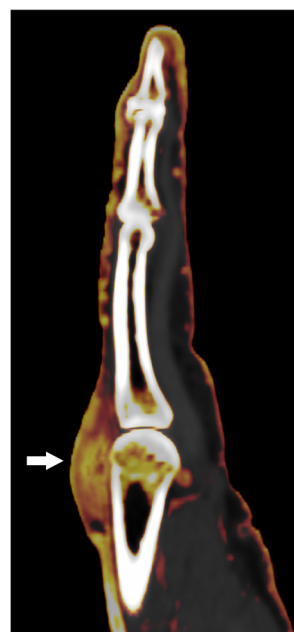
Extensor peritendinitis. Dual-energy computed tomography (DECT) iodine map of a 66-year-old patient with psoriatic arthritis (PsA) showing swelling and marked proximal enhancement in the dorsal part of the second metacarpophalangeal (MCP) joint (arrow)
